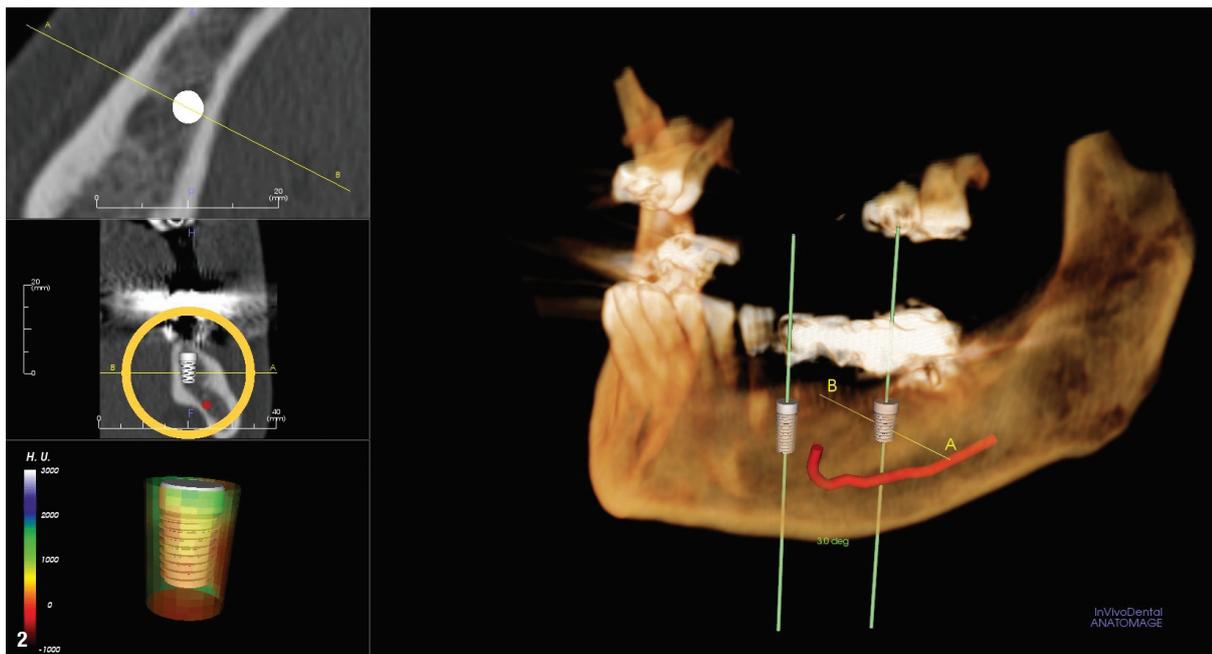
Digital planning with CBCT for implant size.
